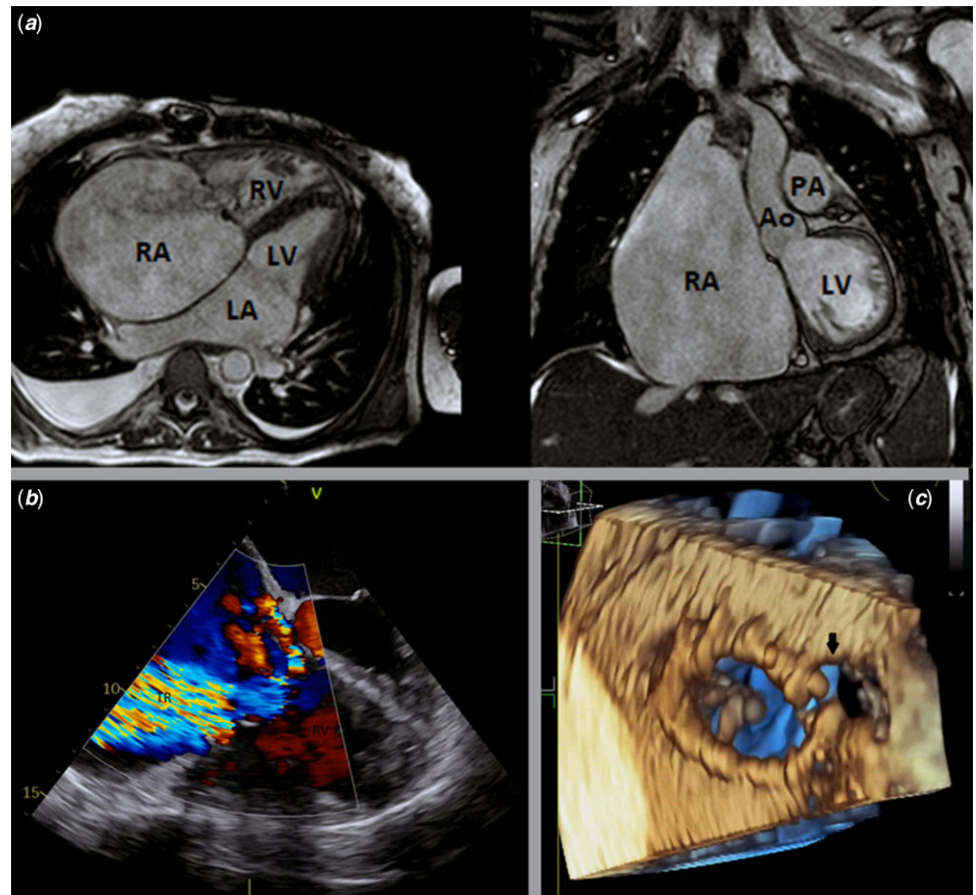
(a) Cardiac magnetic resonance imaging, axial and coronal planes. Note the massive right atrium dilation. (b) 2D transesophageal echocardiography, four chambers view, colour Doppler mode. Carpentier ring in tricuspid position with massive tricuspid regurgitation through the ring. (c) 3D transesophageal echocardiography, mid-esophageal view. Carpentier ring seen from right atrium side. Note the tissue dehiscence adjacent to the opening part of the ring (arrow) (possibly overestimated due to very thin tissue drop-out artifact). Legend: Ao – Aorta; LA – left atrium; LV – left ventricle; PA – pulmonary artery; RA – right atrium; RV – right ventricle; TR – tricuspid regurgitation.
